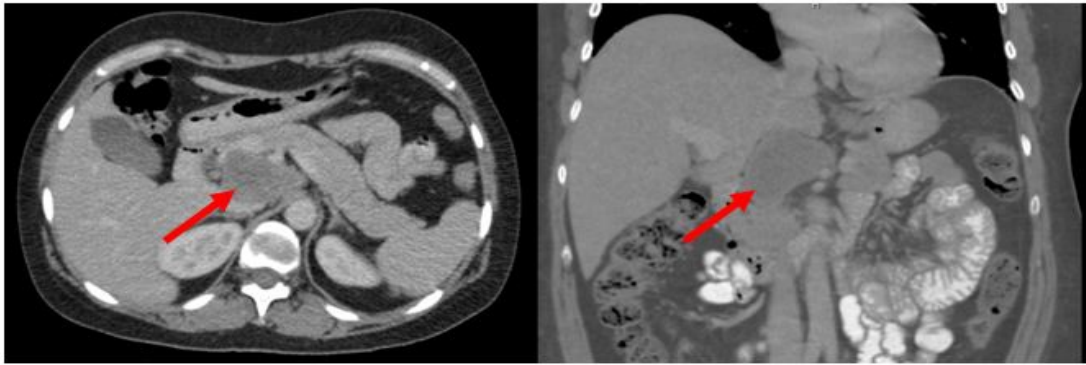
Portal Venous phase CT of Gastric Schwannoma
